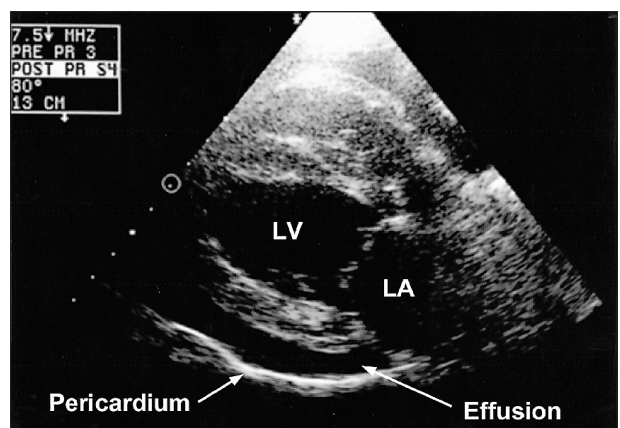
Echocardiograph of the right parasternal long-axis 4-chamber view of the heart of the same 7-year-old Golden Retriever as in Figure 1 at the time of admission. Notice the moderate amount of pericardial effusion and the thick pericardium (0.5 cm width). Pericardial effusion resulted in cardiac tamponade. LA = Left atrium; LV = Left ventricle.
